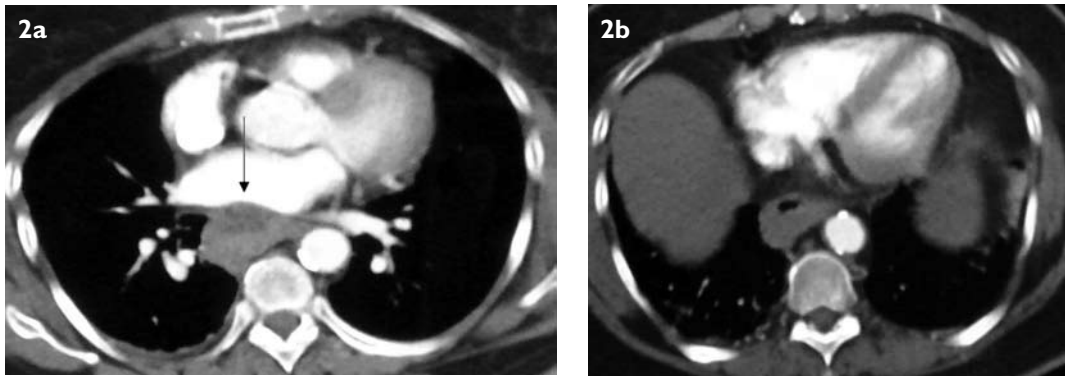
(a) Axial CT image taken at the level of the left atrium shows asymmetric mural thickening involving the oesophagus, with the presence of differential densities and a fluid-fluid level within the oesophageal wall (arrow). There is minimal right-sided pleural effusion. (b) Axial CT image taken at the level of entry of the inferior vena cava into the right atrium, shows a narrowing of the oesophageal lumen and eccentric wall thickening, most evident along its posterior and right lateral walls.
